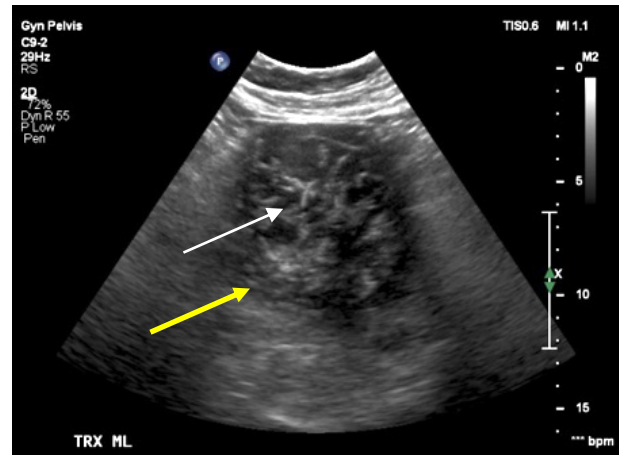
shows representative ultrasound images at baseline, 1-day post-embolization, 1-month, and 6-months post-embolization of a subject treated with OCL 504 (212-300 μ m).
